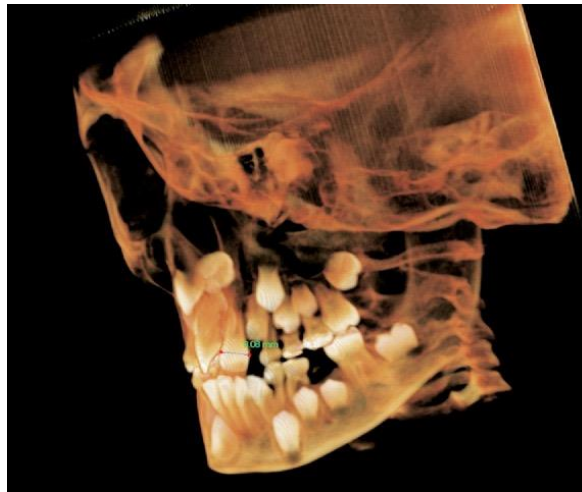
A Cone beam computed tomography scan that helps assess tooth sizes, tooth and root development, arch length, and root proximity. [Adapted from (10)]
